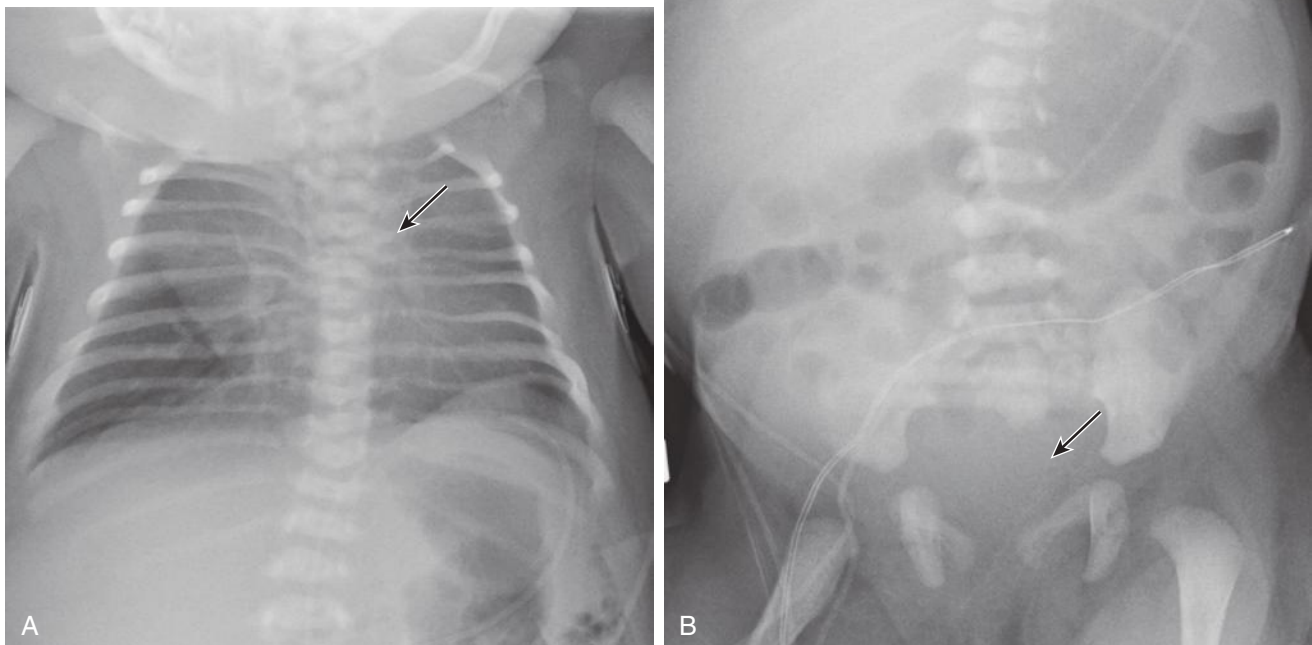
Caudal regression syndrome associated with poorly controlled maternal diabetes. Postnatal radiographs demonstrate vertebral segmentation abnormality (A) (*arrow*) and absent sacrum (B) (*arrow*).
